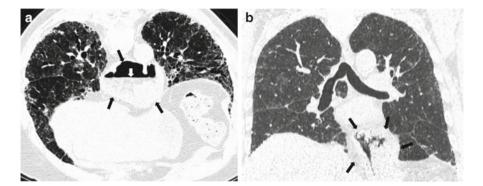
(a) Transverse HRCT image with prone positioning in a patient with advanced parenchymal fibrosis due to IPF showing a large hiatal hernia (*black arrows*) with an internal air-fluid level (*white arrow*). (b) Coronal view showing hiatal hernia (*black arrows*) in a patient with usual interstitial pneumonia on surgical lung biopsy but relatively well-preserved lung function
